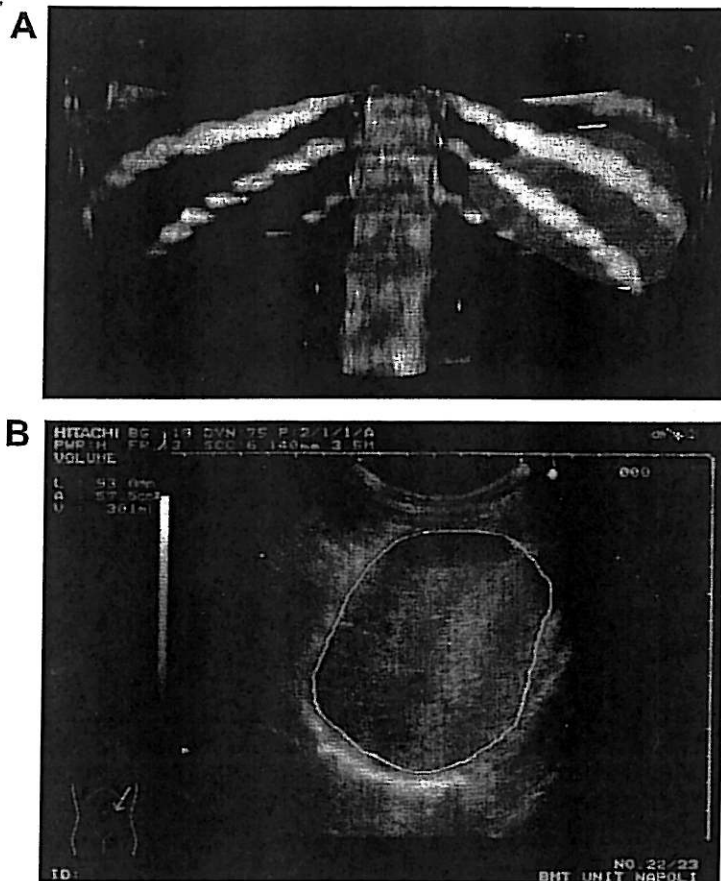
Spleen images obtained by three-dimensional CT scanning (A) and by US scanning (B). In this representative patient (#33) spleen volume was 300 mL by CT scan and 300 mL by US scan.
